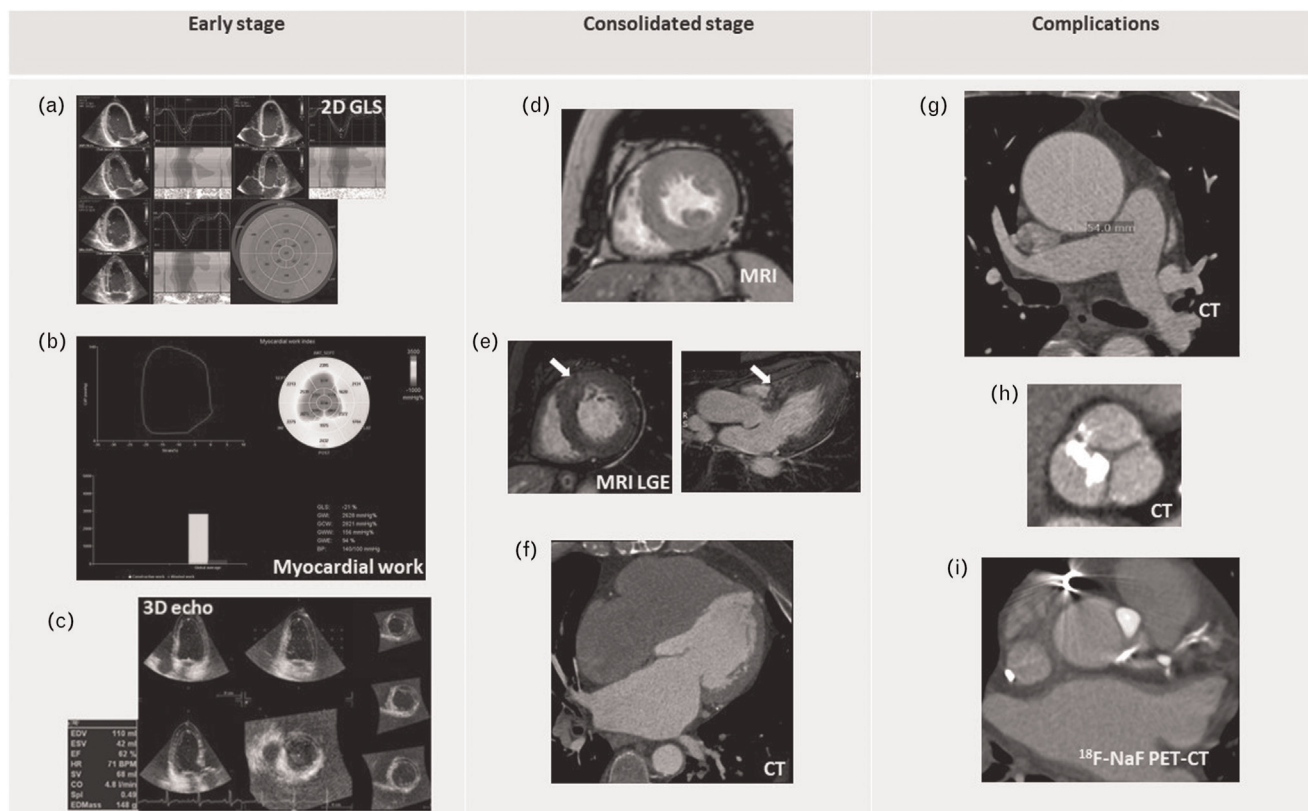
Example showing alterations provided by different advanced imaging tools at early stage, consolidated stage of arterial hypertension and complications. At early stages: (a) 2D GLS and regional strain impairment with predominant involvement of basal and middle longitudinal strain, (b) Myocardial work components alteration in hypertensive patients, (c) LV concentric geometry with increased LVM/EDV ratio detectable at 3D-echocardiography. At consolidated stage: (d) LVH evaluated by MRI, (e) LGE nonischemic intramyocardial pattern (white arrow) of the basal anterior septum (left: basal short axis view, right: three-chamber view) in a hypertensive patient with LVH, (f) contrast-enhanced CT showing LA dilation. Complications: (g) Aneurysm of the ascending aorta detected by contrast-CT, (h) Aortic valve calcification and stenosis by CT, (i) ¹⁸F-NaF PET-CT showing uptake within both the descending left coronary artery and the aortic valve. ¹⁸F-NaF, fluorine-18-sodium fluoride; 2D, two-dimensional; 3D, three-dimensional; CT, computed tomography; EDV, end-diastolic volume; GLS, global longitudinal strain; LA, left atrial; LV, left ventricular; LVH, left ventricular hypertrophy; LVM, left ventricular mass; PET-CT, PET-computed tomography.
